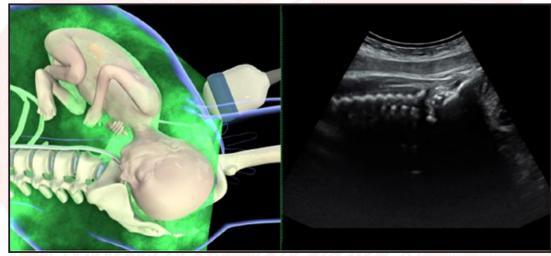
Transabdominal Ultrasound Imaging of the fetus (in occiput-anterior position) in the sagittal plane.
